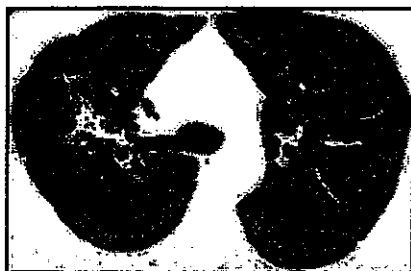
Transverse thin-section CT scan in 36-year-old man at follow-up (obtained at day 43 after admission, 26 days since discharge) shows evidence of fibrosis. Large areas of ground-glass opacification are still present, both surrounding the areas of fibrosis and in other regions.
